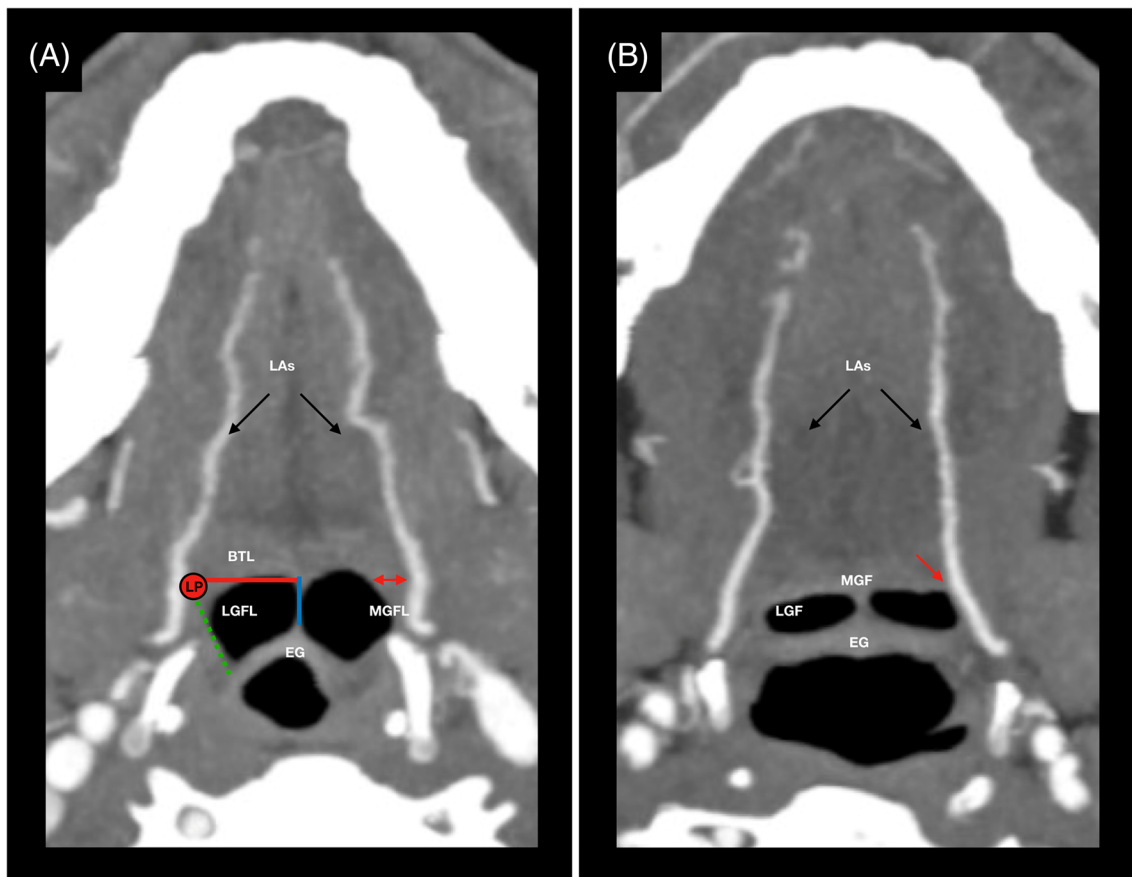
Depth variability of the lingual artery at the LP from the overlying mucosa. Curved maximum intensity projection CTA of the lingual arteries in two subjects. Image A shows a regular case, where both lingual arteries pass some millimeters deep to the mucosal surface at the level of the LP point, which is identified at the crossing point between the LGFL (green dotted line) and BTL (red lines). The red double arrow depicts the lingual artery depth. Image B shows a peculiar scenario, where the left lingual artery has a superficial path, almost reaching the mucosal surface (red arrow). BTL, base of tongue line; Eg, epiglottis; LAs, lingual arteries; LGFL, lateral glosso-epiglottic fold; LP, lingual point; MGFL, median glosso-epiglottic fold [Color figure can be viewed at wileyonlinelibrary.com]
